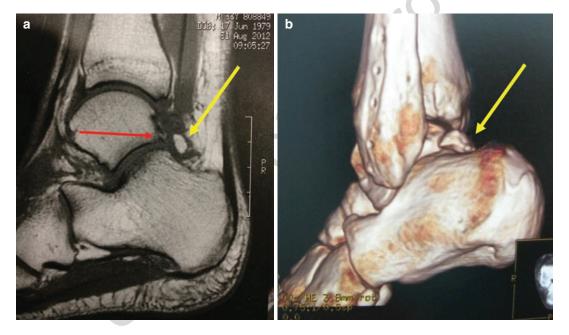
(a) MRI with synovitis and inflammatory tissue surrounding an *os trigonum* (yellow arrow); (b) 3D CT showing posterior entrapment of *os trigonum* (yellow arrow)
